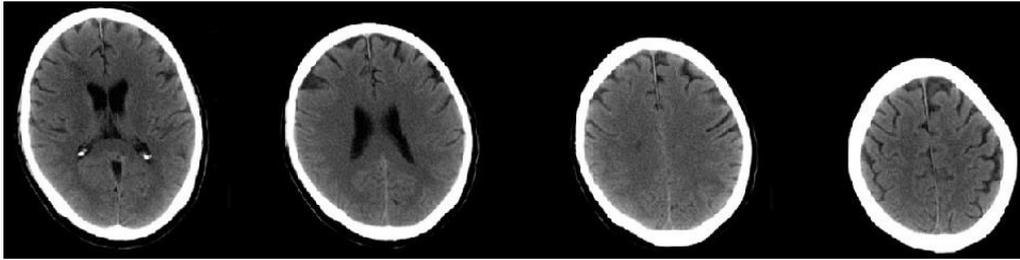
CT head without contrast, pre-transplantation, demonstrating chronic injury of the right frontal and centrum semiovale.
